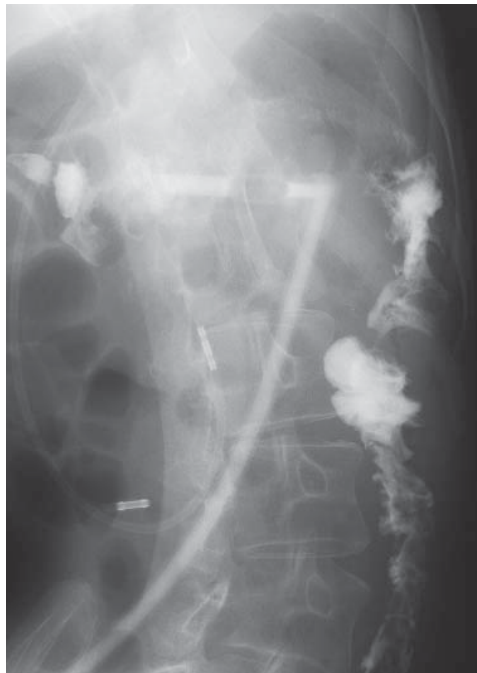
Radiographic study with gastrografin shows the tip of the tube in lumen of transverse colon with colonic filling to descending colon.
